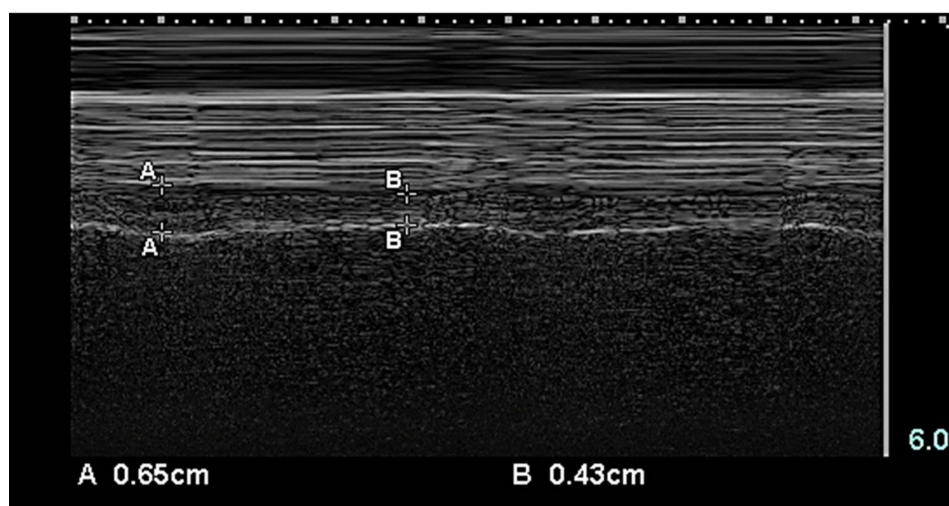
Diaphragmatic thickness fraction is measured in M-mode ultrasonography at the area of lung opposition. Point A is the end-inspiratory thickness, and point B is the end-expiratory thickness. The thickness fraction is the end-inspiratory thickness minus end-expiratory thickness divided by the end-expiratory thickness and presented in percentage.
